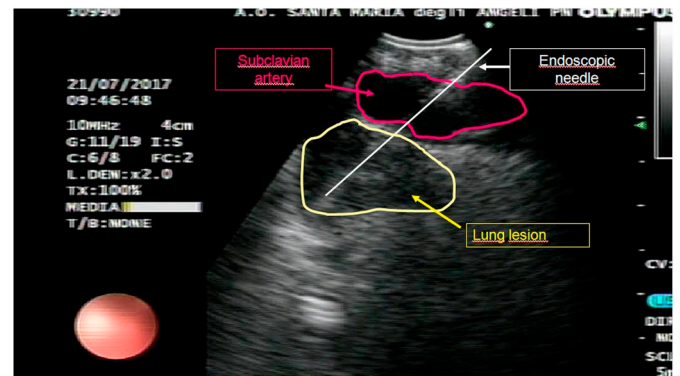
Endosonographic view of the EUS-B scope showing needle in the mass traversing through the subclavian artery.
